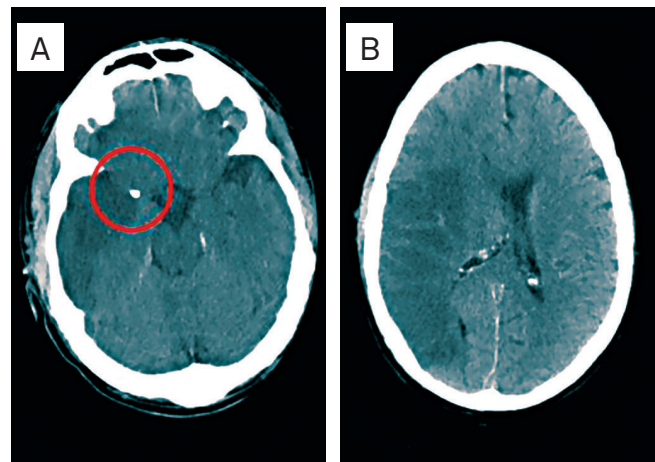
Computed tomography shows calcific embolus (circle) of the M1 segment of the right middle cerebral artery (A); extensive right frontal-parietal area of hypoattenuation involving the territory of the right middle cerebral artery (B).
